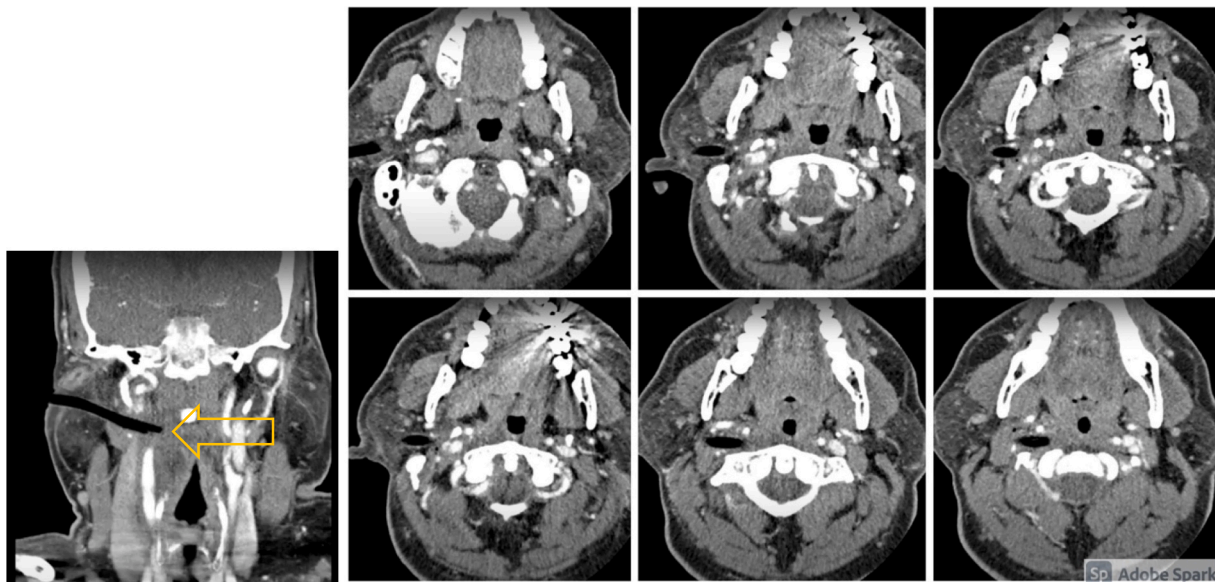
Neck CTA revealing the penetrating foreign body traversing through the parotid gland with disruption of the internal jugular vein.
